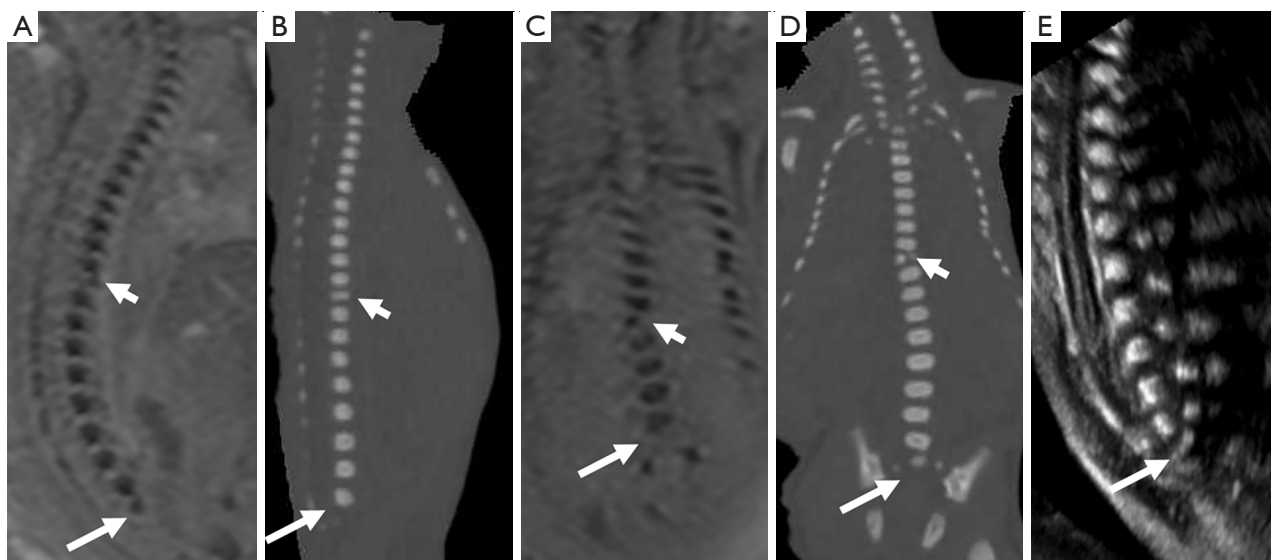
Sacrococcygeal hypoplasia. (A-E) Case 124, (A, C) the spine ends at S1, and the sacrum was not visible below S1 (long arrows) in sagittal and coronal SWI images at 26 w and complicated with T9 hemivertebrae (short arrows). (B, D) These findings were consistent with the postmortem CT (arrows). (E) US shows dysplasia of the sacrococcygeal vertebrae (arrow); however, the T9 hemivertebrae was missed in prenatal diagnosis. SWI, susceptibility-weighted imaging; CT, computed tomography; US, ultrasound.
